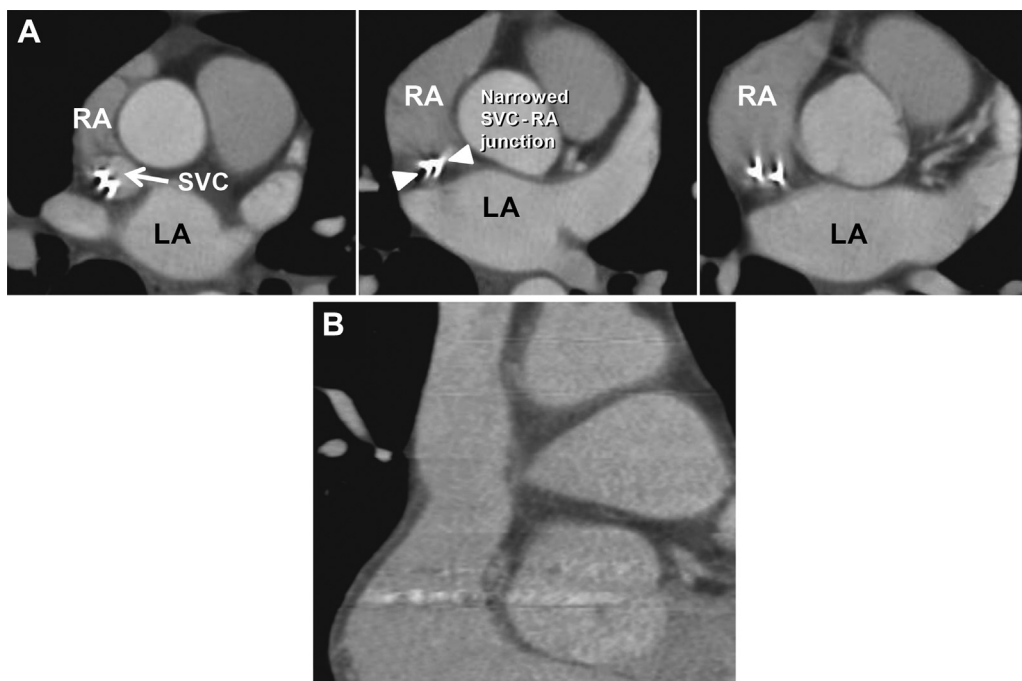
A: Serial axial images on computed tomography show persistent stenosis after attempted percutaneous venoplasty. The superior vena cava (SVC)–right atrium (RA) junction remained significantly narrowed; only the pacemaker leads are visualized at the junction (*arrowheads*). B: Computed tomography scan after surgical patch venoplasty shows widely patent SVC and SVC-RA junction (*arrow*). LA = left atrium.
